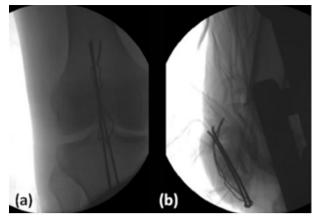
(a) Postoperative two month AP; (b) lateral radiographs present fracture healing
